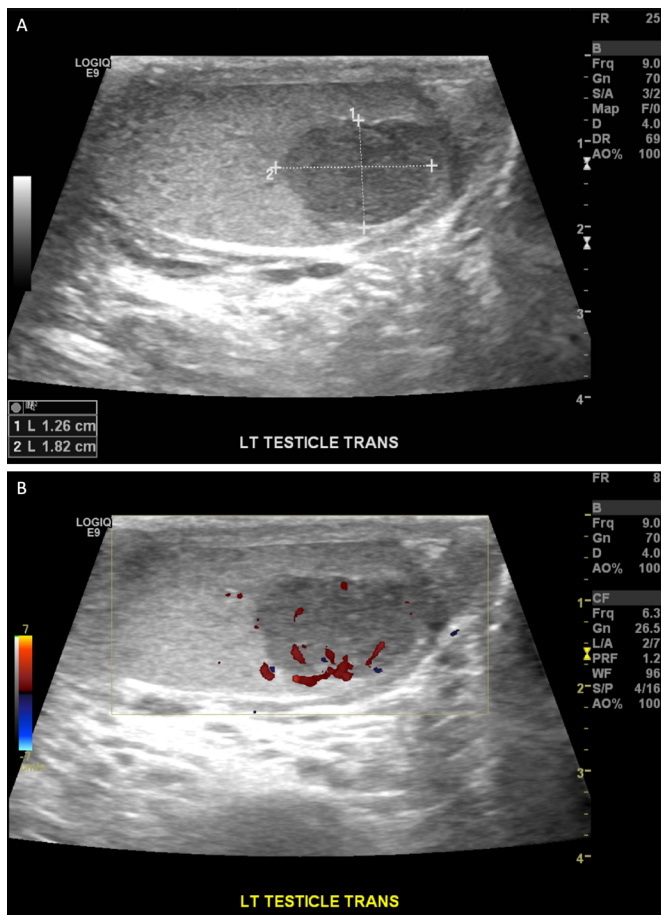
Representative ultrasound images of the testicular mass. (A) The mass is hypoechoic and measures about 1.3 by 1.8 cm in size. (B) Evidence of blood flow to the tumour on Doppler imaging.
